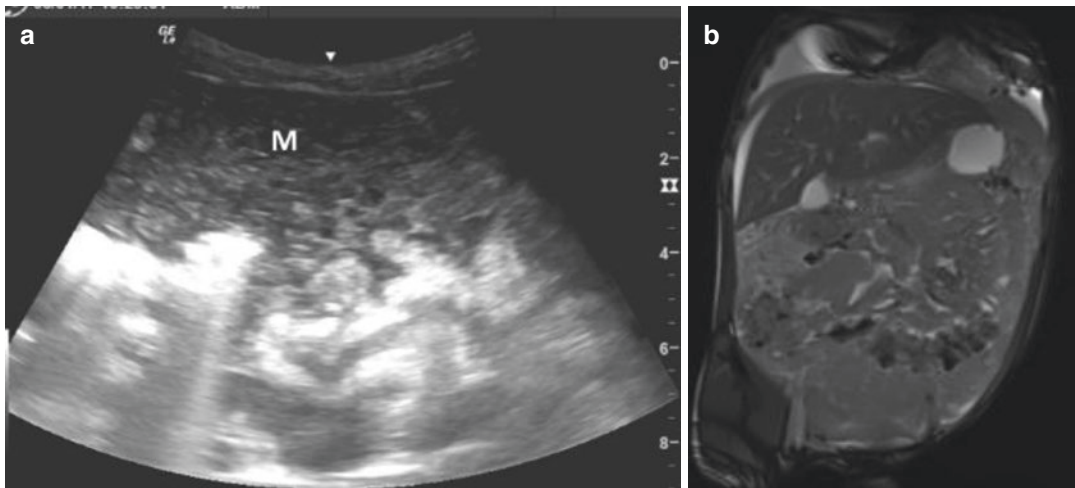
Burkitt lymphoma diffuse type—7-year-old boy. (a) US—echogenic heterogeneous mass filling the anterior peritoneal space and displacing the bowel loops backwards. (b) MR imaging—T2-weighted sequence—
